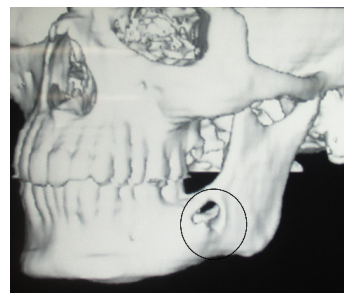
Computed tomogram 3 D reconstruction reveal through and through buccal and lingual cortical expansion. Inferior border of mandible is intact without any destruction/expansion.
